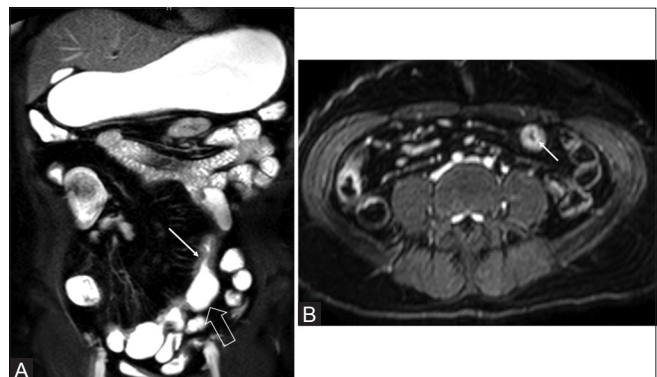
(A and B): Pseudosacculations in fibrotic CD. Coronal T2-weighted image (A) of MRE study showing wall thickening and multiple segments of luminal narrowing involving the ileal loops (thin arrow). Pseudosacculations are seen along the antimesenteric border (outlined arrow). Axial postcontrast T1-weighted image (B) shows homogeneous wall enhancement of the involved loop. These features are characteristic of fibrostenotic stage of CD
